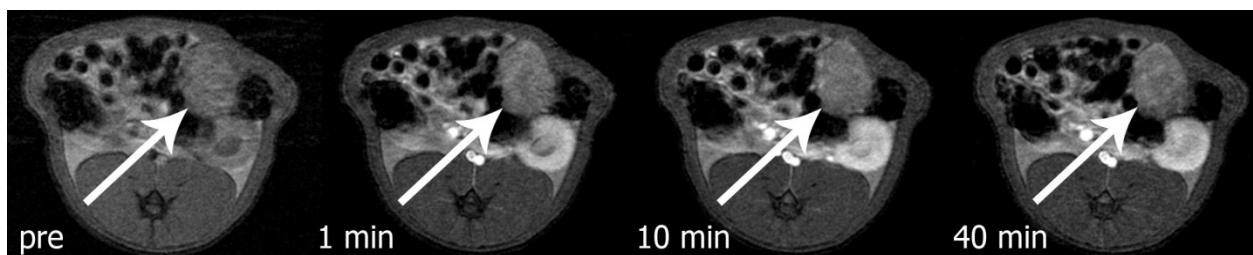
Representative dynamic T1-weighted images of an orthotopically implanted pancreatic cancer after 4 weeks of angiogenesis inhibition (suramin)
